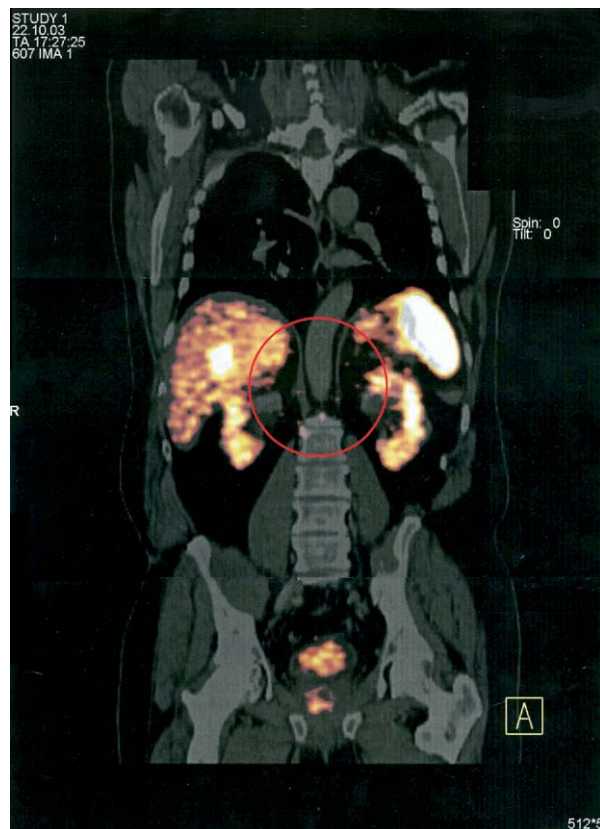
Anterior ^{68}Ga -DOTATOC PET/CT image (85 MBq) in a patient with multiple liver and abdominal lymph node metastases (*circle*) of a neuroendocrine pancreatic tumor.
